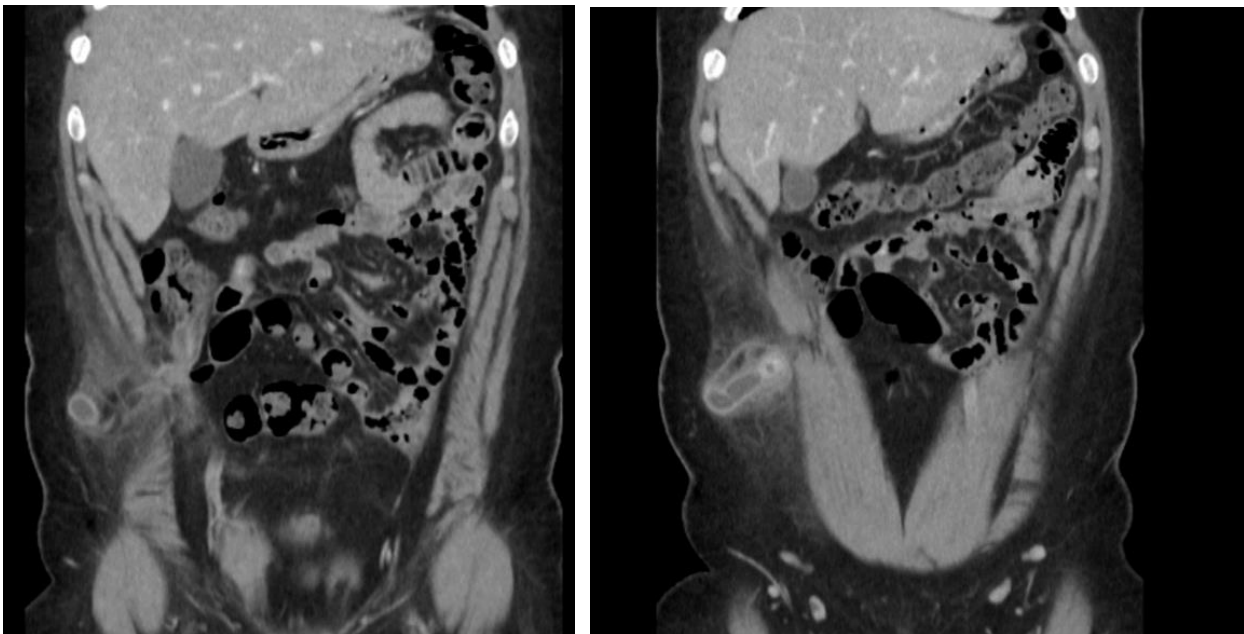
Sections of the abdominal CT scan in the coronal plane are depicted. It was initially thought to show an incisional hernia containing a loop of the bowel. Intraoperatively, however, an inflamed appendix was seen to herniate through the Spigelian hernia defect on the right side. Thus, the diagnosis was made intraoperatively at the time of laparoscopy.
